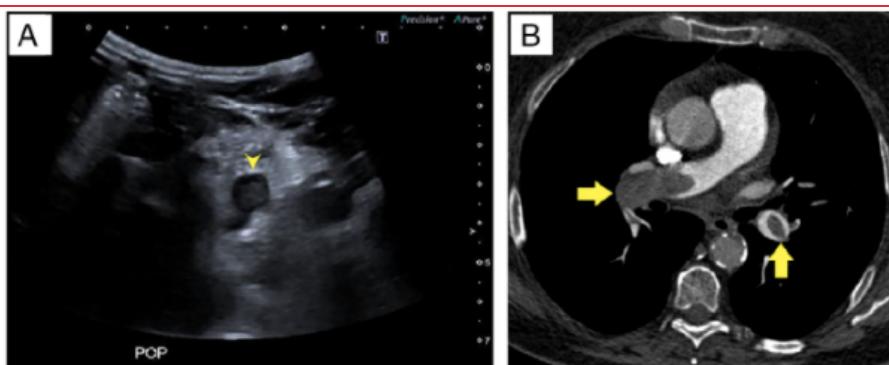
A, Thrombosed popliteal vein. Transverse ultrasound scan shows an echogenic clot in the left popliteal vein (arrowhead). B, Bilateral PE. Computed tomographic pulmonary angiography shows bilateral filling defects in the right pulmonary artery and the left lower lobar artery (arrows).
